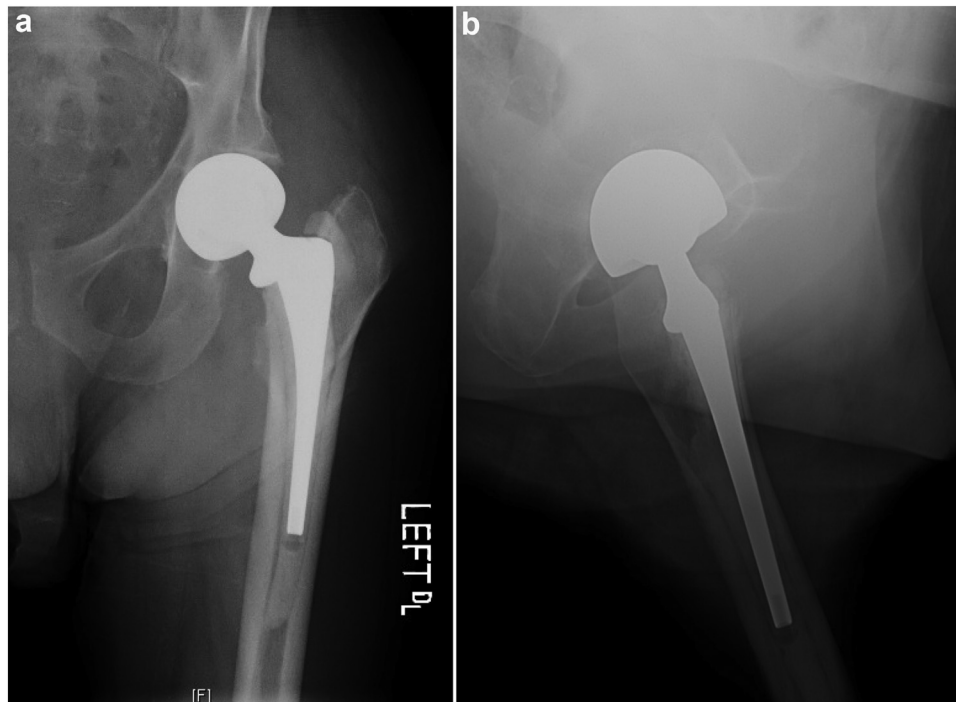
Radiographs at 16-month follow-up. Anteroposterior (a) and lateral (b) radiographs of the left hip at 16-month follow-up demonstrating stable components and no signs of osteolysis.
